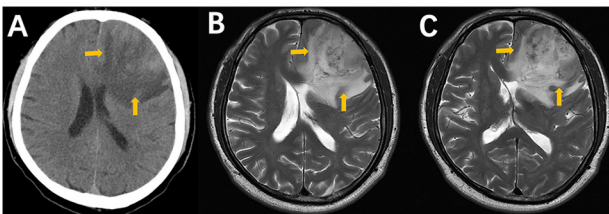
Images taken subsequent to the glioma's detection. (A) Hemorrhagic lesions in the left frontal lobe, exhibiting substantial abnormal density and space-occupying bleeding, as well as cerebral hernia (yellow arrows) on November 2023 (CT). Incisions with differing degrees of midline shift can be distinguished. (B) Left frontal space-occupying lesion compressing the lateral ventricle. Heterogeneous necrotic core with solid components and thick irregular rim enhancement, and absent cystic walls, pathognomonic of high-grade glioma. (C) The space-occupying lesion results in a more pronounced rightward midline shift, more severe compression and deformation of the lateral ventricle, and more prominent garland-like abnormal signal intensities on imaging. Left frontal occupation, which is identified as a high-grade glioma (yellow arrows) on November, 2023 (MRI).
